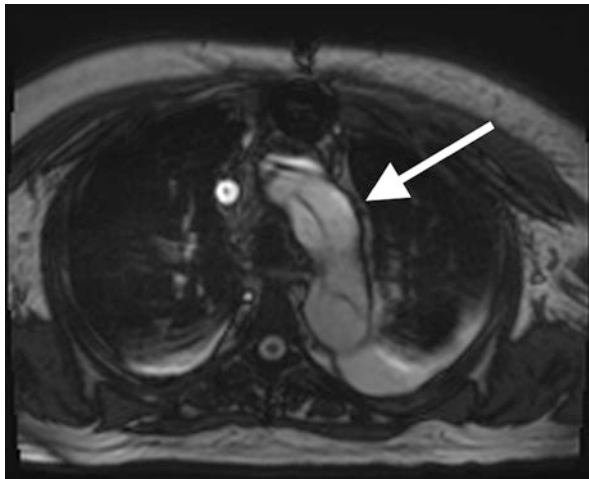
MRI angiography of a patient with an acute dissection tear extending from the ascending aorta along the descending aorta along with the aortic arch (arrow). Bilateral pleural effusions are observed. No contrast was needed for this MRI
